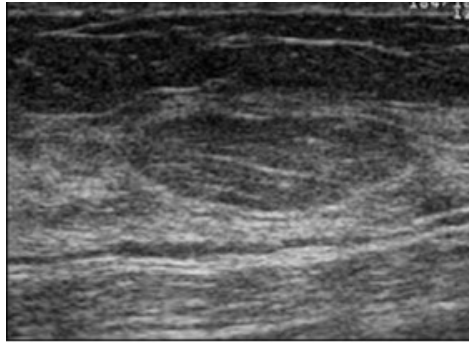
Sample ultrasound images representing different types of cysts.
